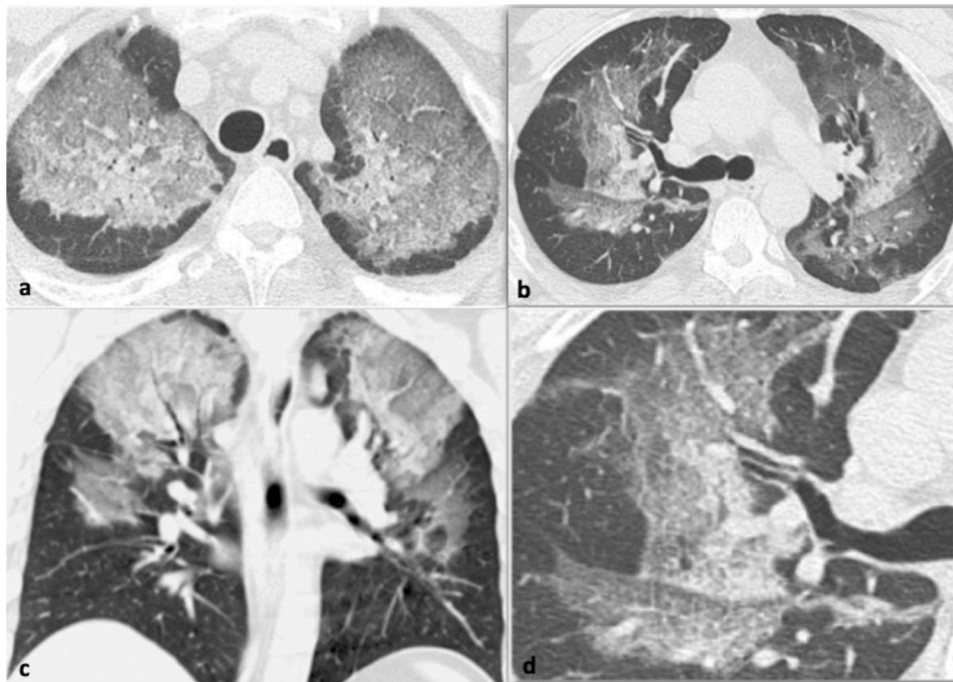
31-year-old male with pneumonia due to MERS coronavirus who presented with cough and sputum. 7a-c. Axial and coronal CT images show bilateral symmetrical ground glass opacity with an upper and mid zone distribution. 7d. Small field of view in the right upper lobe at the level of the carina demonstrates a crazy-paving pattern.
